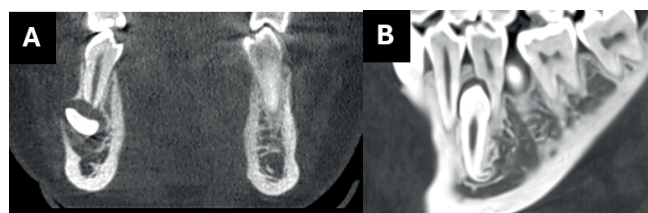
Representative CBCT images of ST-related root resorption A. Root resorption of premolar tooth in the coronal section B. Root resorption of premolar tooth in the sagittal section.
